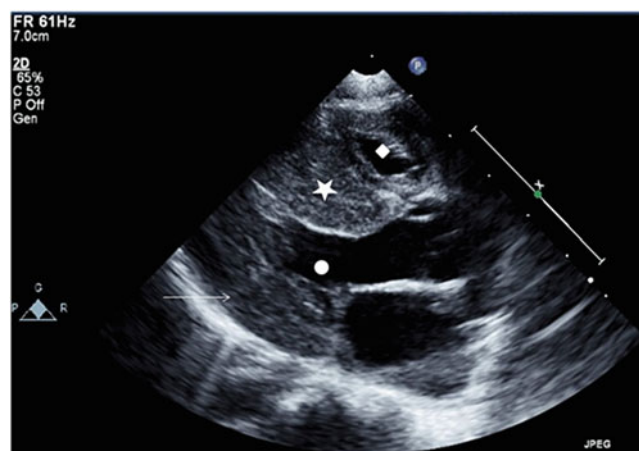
Echocardiogram: parasternal long-axis view demonstrating septal (filled star) and left ventricular posterior wall thickening (arrow) with crowding of both the left (filled circle) and right ventricular cavity (filled diamond)
